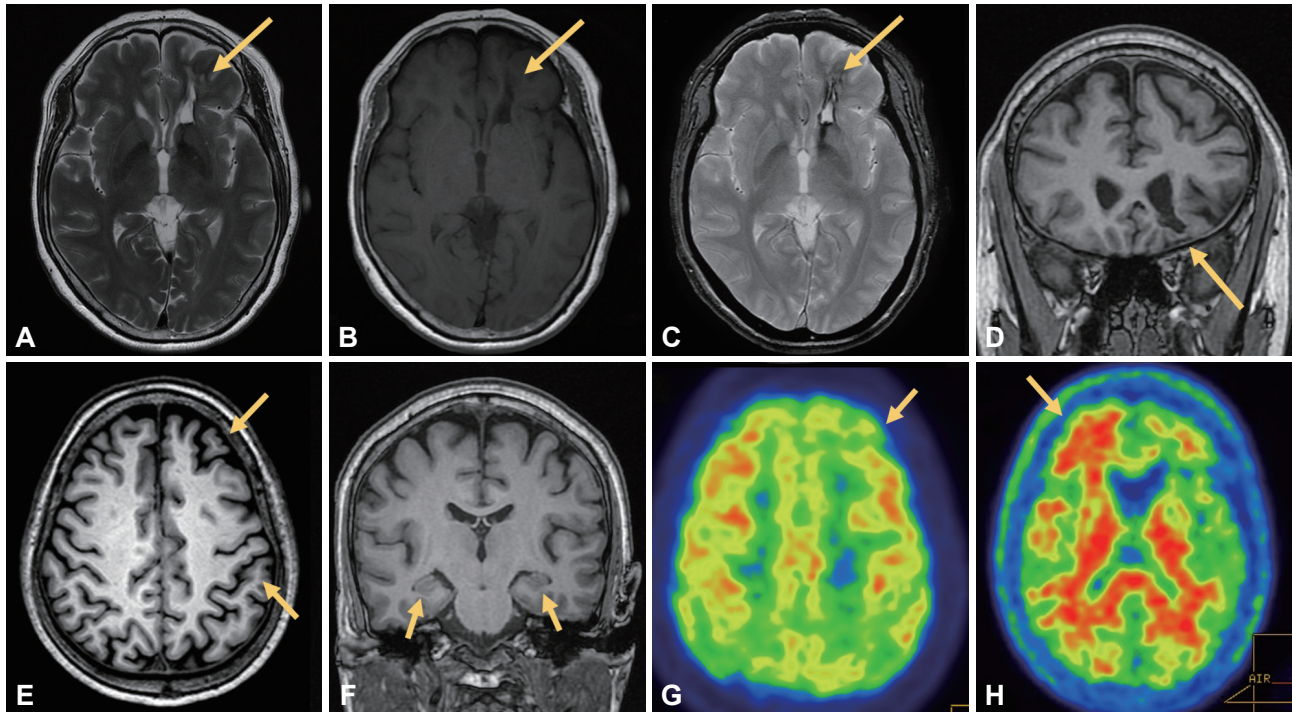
Brain magnetic resonance imaging (MRI) (A-F) and ^{18}F -flutemetamol amyloid positron-emission tomography (PET) (G and H). Brain MRI showed encephalomalacic changes in the left orbitofrontal cortex, suggesting an old hemorrhagic stroke (A-D). Mild cortical atrophy was evident in the frontal and parietal lobes, whereas hippocampal atrophy was grossly unremarkable (E and F). Early dynamic brain ^{18}F -flutemetamol amyloid PET images acquired 10 min after injecting ^{18}F -flutemetamol reveal decreased uptake in the bilateral parietal and left dorsolateral prefrontal regions as well as in the damaged left orbitofrontal region (G). Delayed brain images obtained 90 min after the injection reveal amyloid deposition in the right frontal lobe (H).
